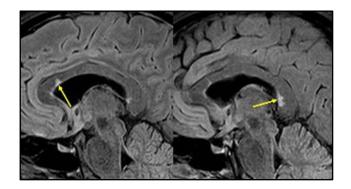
MRI T2-FLAIR corpus callosum region.
